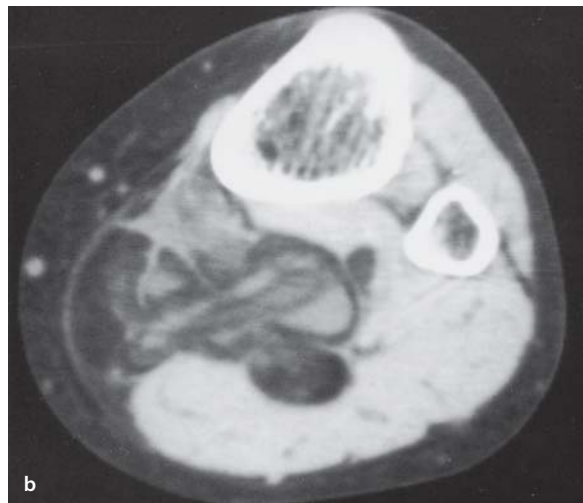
a, b. Low-grade liposarcoma arising behind the knee joint in a 55-year-old woman. a Plain radiograph. b Computed tomography (CT). Fat density areas are visible on the radiograph (a) with mixed fat and soft tissue attenuation on CT (b)
